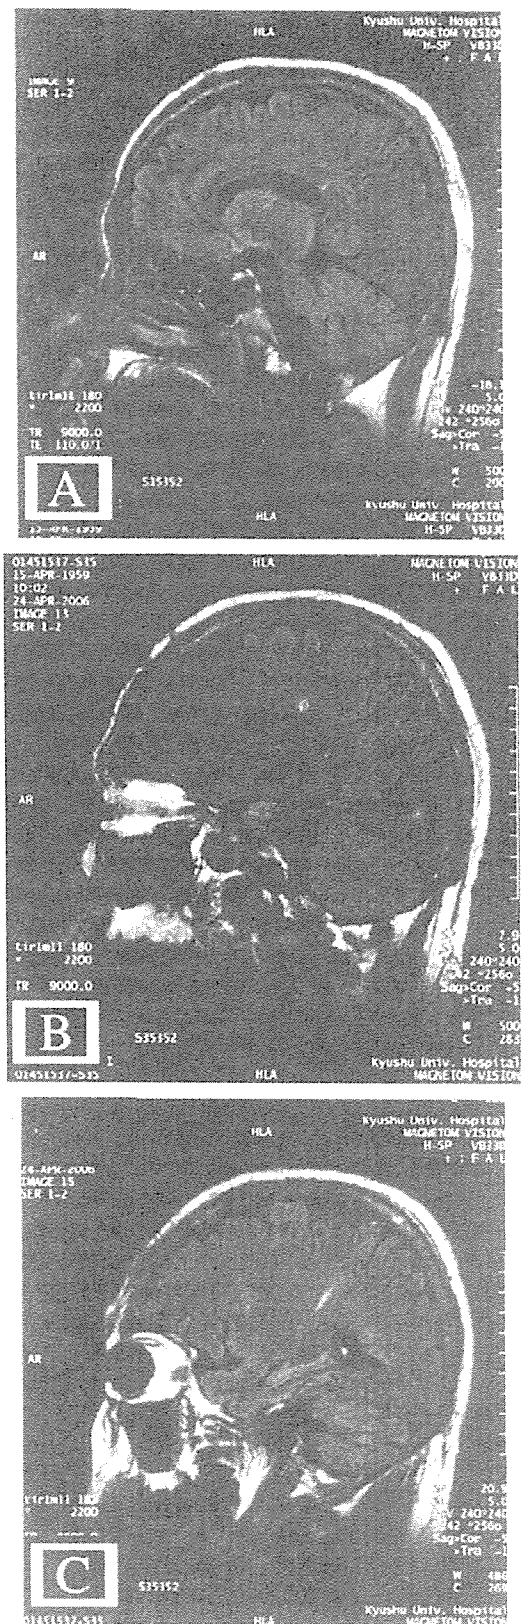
Brain MRI of Patient No. 17. Sagittal fluid-attenuated inversion recovery (FLAIR) images (TR=9000 ms, TE=110 ms) of a 46-year-old male demonstrating multiple ovoid lesions of increased signal intensity in the corpus callosum, bilaterally, and in the left parietal and occipital lobes which appeared MS-like. [A] to [C]: right to left side of the patient.
